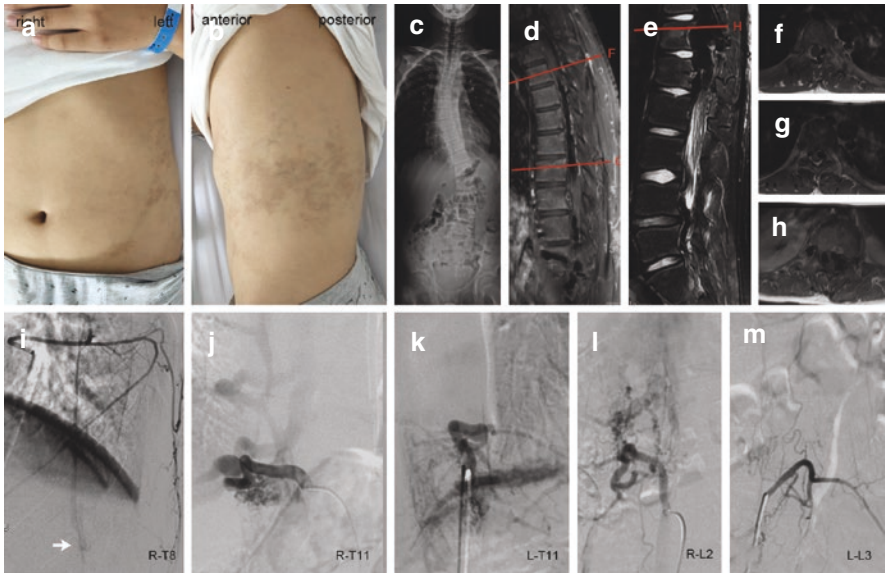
A case of pediatric Cobb's syndrome (12-year-old boy) with predominantly paravertebral arteriovenous malformations. The child initially presented with low back pain and weakness of bilateral lower limbs, and the symptoms worsened in 9 months before admission. (a, b) Rash on lateral chest and abdomen. (c) Full-length spine plain film showing scoliosis deformity at the time of onset. (d–h) MRI T1 WI enhancement sequence and T2 WI sequence suggest abnormally dilated flow void at paravertebral and subcutaneous regions (red line shows the section location of f–h). (i) Lateral view of right T8 intercostal artery injection. The arrow indicates the intramedullary vascular malformation at the conus medullaris. (j–m) The results of the superselective intercostal and lumbar artery injection, suggesting to paravertebral arteriovenous malformations with medium-flow fistulas in the lesions. *T* thoracic, *WI* weighted image
